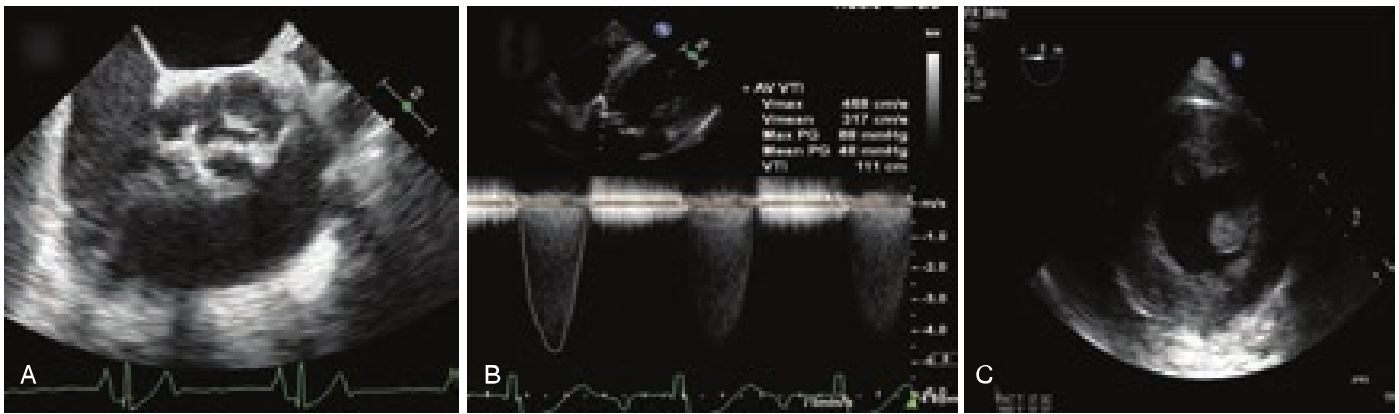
Transesophageal echocardiography images of patient with characteristic features of severe aortic stenosis. (A) Midesophageal short-axis view showing severely calcified aortic valve with a small valve area. (B) Deep transgastric view with continuous wave Doppler through aortic valve showing high peak velocity along with high peak and mean gradients. (C) Transgastric short-axis view showing compensatory concentric left ventricular hypertrophy.
